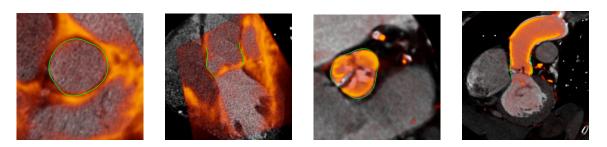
Example of the joint aortic valve model estimation from pre- and intra-op volumetric data. The left 2 images show fused CT-TEE data sets and the right 2 images show fused CT-3D C-arm CT data. The mapping of the intra-op image I_2 to the pre-op image I_1 is done by the estimated non-linear transform ϕ .
